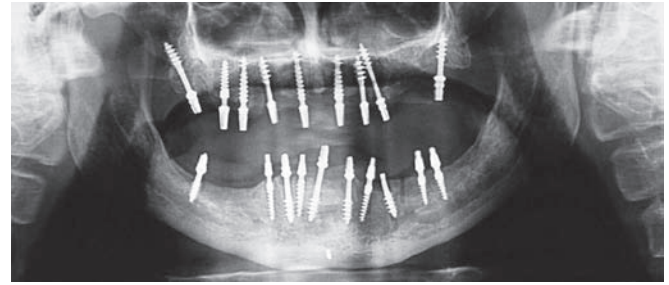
Orthopantomogram showing basal implants placed in maxillary and mandibular arch
